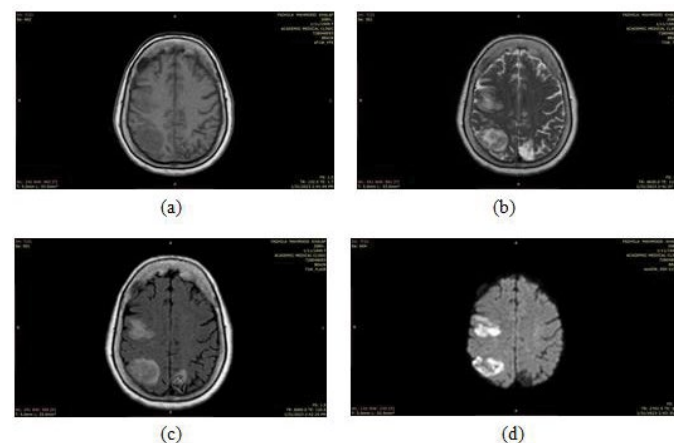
States the subacute stroke taken by (a) (T1W) sequence, (b) (T2W) sequence, (c) (FLARE) sequence, (c) (DWI) sequence.
